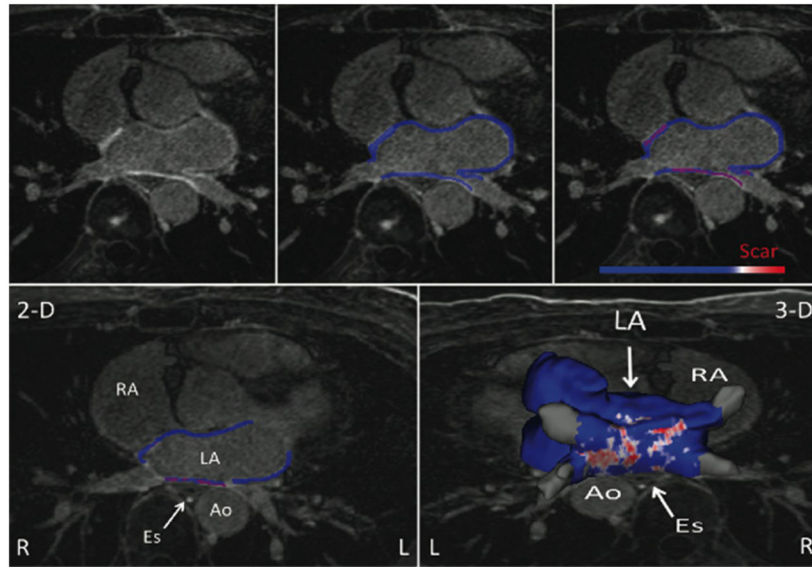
The left atrial wall segmentation on the LGE-MRI and serial steps taken to determine scar formation in the entire left atrium. *Top row* shows axial LA MR image (*left*), segmented LA wall (*middle*), and enhanced area marked as scar (*right*). *Bottom row* shows one segmented slice (*left*) and all the slices put together for the entire LA (*right*)
